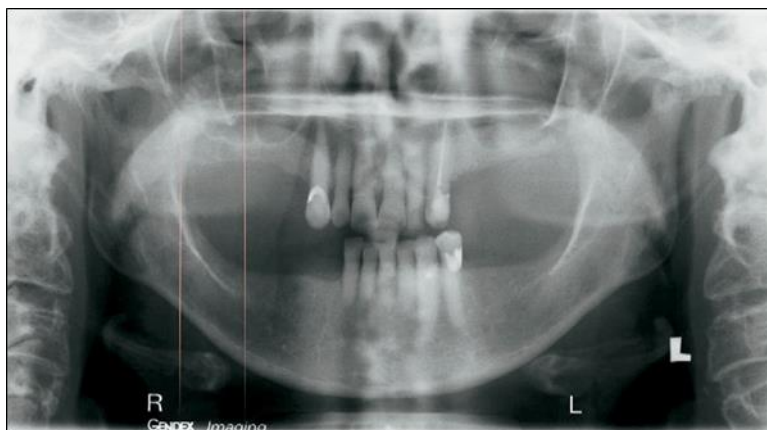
Storage phosphor-based (DENOPTIX, Gendex, Chicago, IL) digital panoramic radiograph
